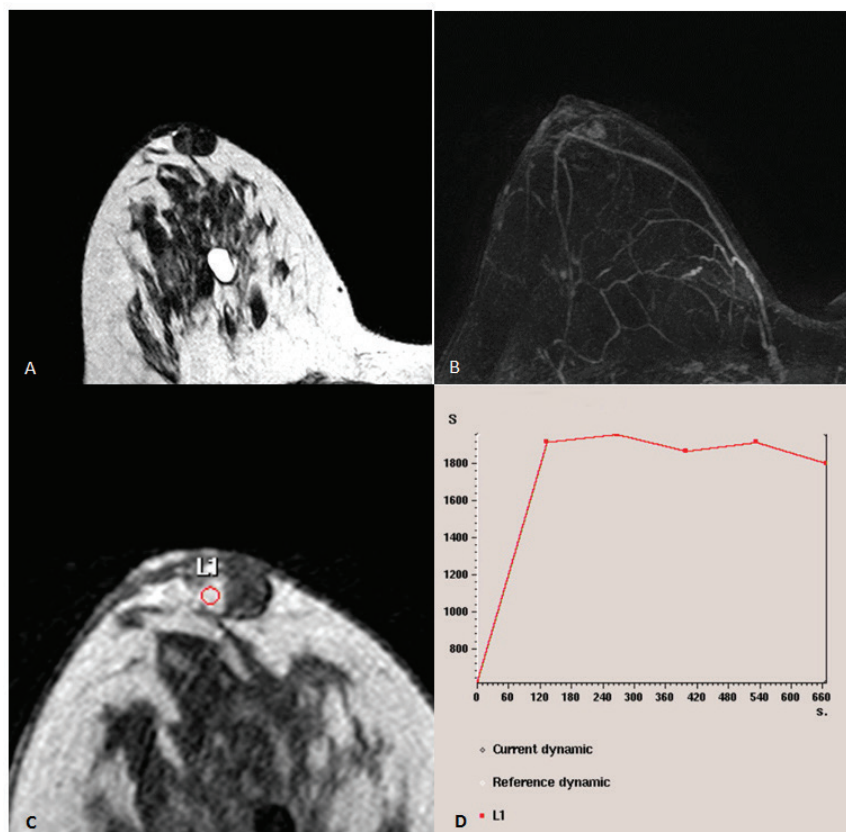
MRI image of the breast with dynamic contrast enhancement shows an 18-mm lobulated T2-hypointense mass (panel A) with the medial part of persistent enhancement in the inner periareolar region of the right breast on axial contrast material-enhanced subtraction MR image (panel B). The superimposed kinetic curve (panel D) derived from measurement in a selected region (red circle in panel C) within the lesion, shows a gradual increase in signal intensity that persists from the initial phase through the delayed phase of enhancement.
